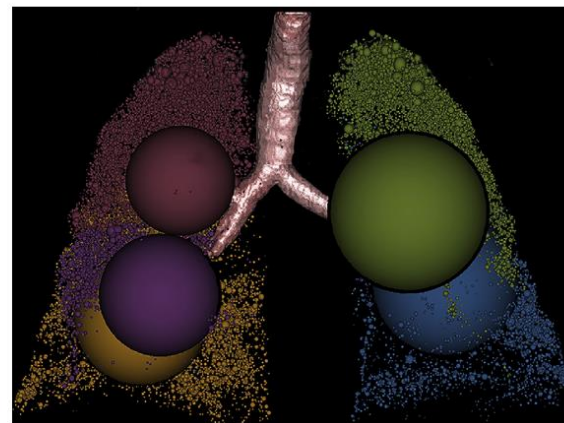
Chest CT for lung density. A, Three-dimensional volume rendition of the lung, lobes, and bronchial tree detected from a CT image of the fully inflated (total lung capacity) lung of a healthy subject. B, CT scan of the chest showing a similar volume rendition using the expiratory image (in this case functional residual capacity) of a patient with severe asthma. Note the areas of air trapping and pruning of the airways. Image processing was derived by using Apollo software (VIDA Diagnostics, Coralville, Iowa).
